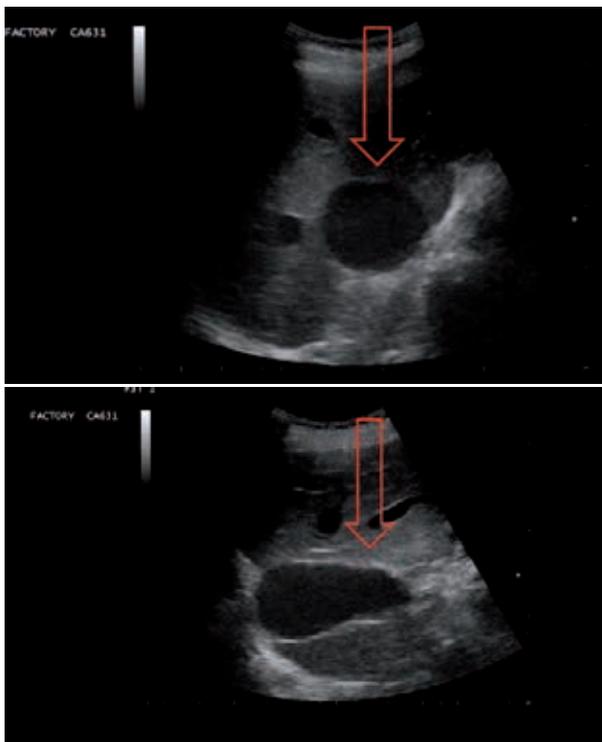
A dilatated IVC (IVC diameter > 20 mm) rules out hypovolemia; IVC is measured in the sub-xiphoid space in the long and transversal axis, using the liver as a sonographic window.
